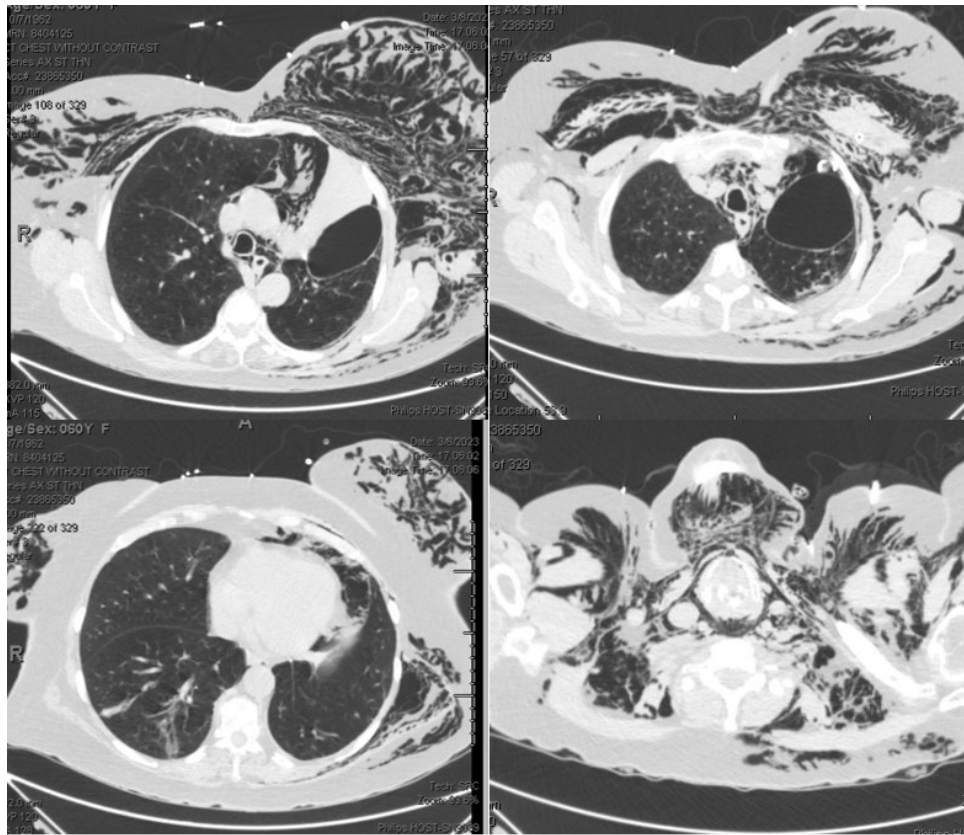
Case 1 - Computed Tomography Chest Post-BLVR Bullae and Subcutaneous Emphysema
